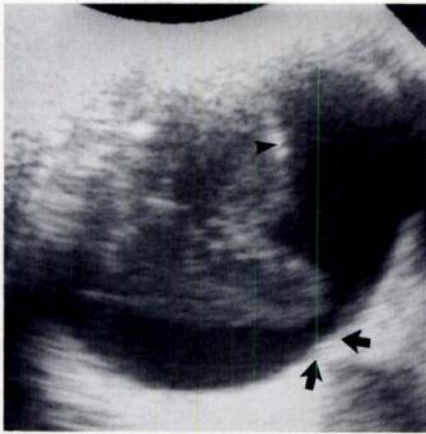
Vitreous detachment. Axial sonogram shows posterior surface of detached vitreous as an echogenic line (*arrowhead*). Echogenic vitreous shows a characteristic swirling movement on dynamic scanning. Vitreous is not attached at site of optic nerve head (*arrows*).
